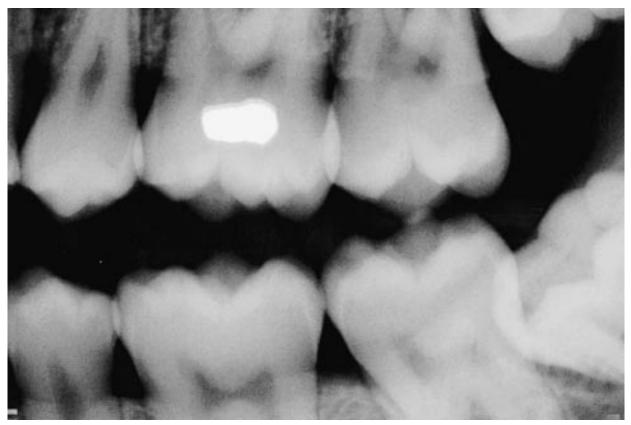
Postmortem bitewing radiograph demonstrating excessive horizontal angulation overangulation.
